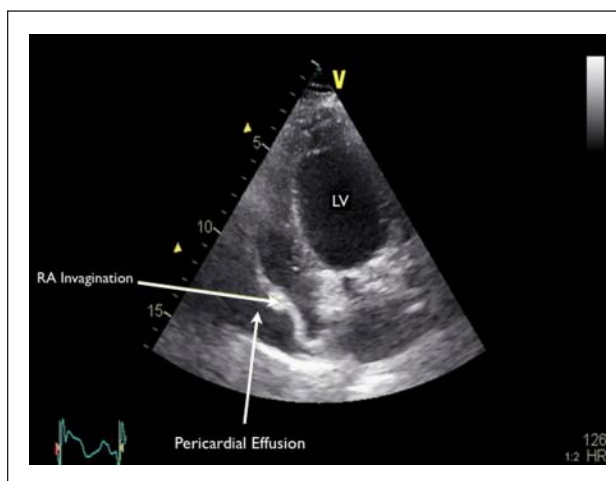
Transthoracic echocardiography apical 4-chamber view of a large pericardial effusion. The right atrial invagination shown here is a specific sign of cardiac tamponade. Abbreviations: RA, right atrium; LV, left ventricle.
